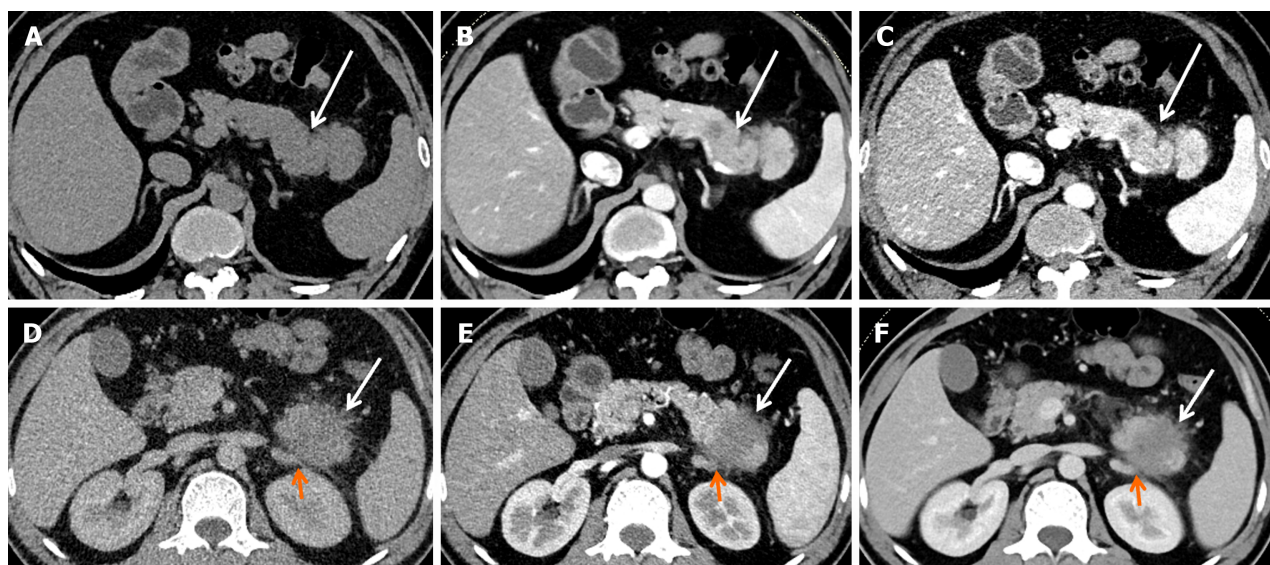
Computed tomography images of two representative cases of pancreatic ductal adenocarcinoma. A-C: A 54-year-old man with stage IB pancreatic ductal adenocarcinoma (PDAC). Computed tomography (CT) imaging showed a well-defined, predominantly solid tumor (white arrow), 3.0 cm in diameter in the tail of the pancreas. No obvious lymph node metastasis, vascular invasion, or distal metastasis was found. TNM classification: T2N0M0 (IB); D-F: A 44-year-old man with stage IV PDAC. CT imaging showed an ill-defined, predominantly solid tumor (white arrow), 4.1 cm in diameter in the tail of the pancreas. The left adrenal gland (orange arrow) was grossly invaded by the tumor. TNM classification: T3N1M1 (IV).
